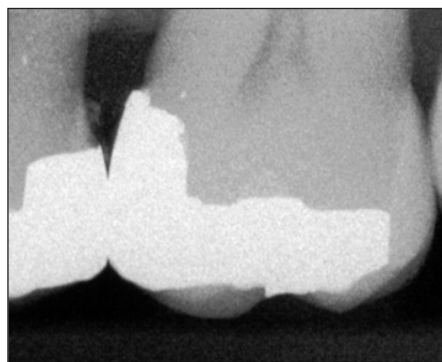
Radiographic image of the corrected restoration. Note the truncated appearance of the restoration.
